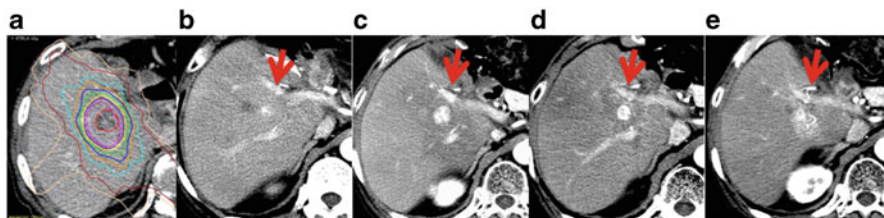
The dynamic computed tomographic appearance of tumor responses (arterial phase). (a) Dose distribution (48 Gy/4 fractions). (b) Before stereotactic body radiotherapy (SBRT), early arterial enhancement is visible (*red arrow*). (c) After 2 and (d) 6 months, early arterial enhancement is more evident than before SBRT (*red arrow*). (e) After 11 months, enhancement remains, although the tumor is shrinking (*red arrow*)
